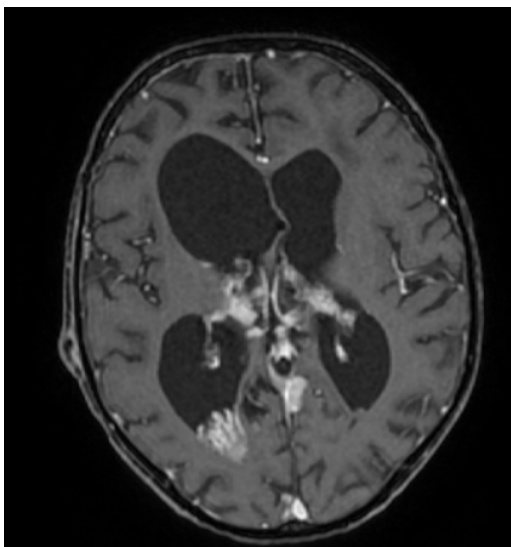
Brain MRI - Polylobulated mass at the level of ventricular ependymal lining – suggestive for leptomeningeal dissemination
